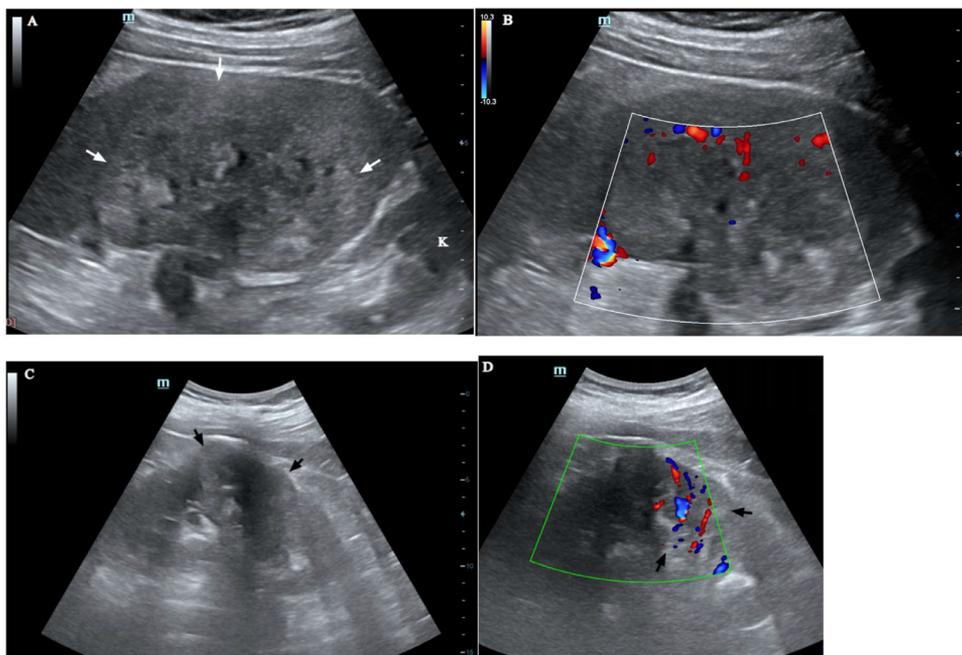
Transverse Gray (A) and doppler (B) mode sonography of the spleen and longitudinal Gray (C) and doppler (D) mode sonography of the left kidney: A relatively hyperechoic splenic hilar lesion (white arrows in A) with heterogeneous central echo-content. Upper pole of left kidney (k) is seen in the left lower corner of the image. There is paucity of flow in the center of the lesion (B). The renal lesion is heterogeneously hypoechoic and deforms the left renal contour (black arrows on C). Although there is some bowel gas shadowing on the color doppler (D), the visible part of the lesion shows significant flow (black arrows in D).
